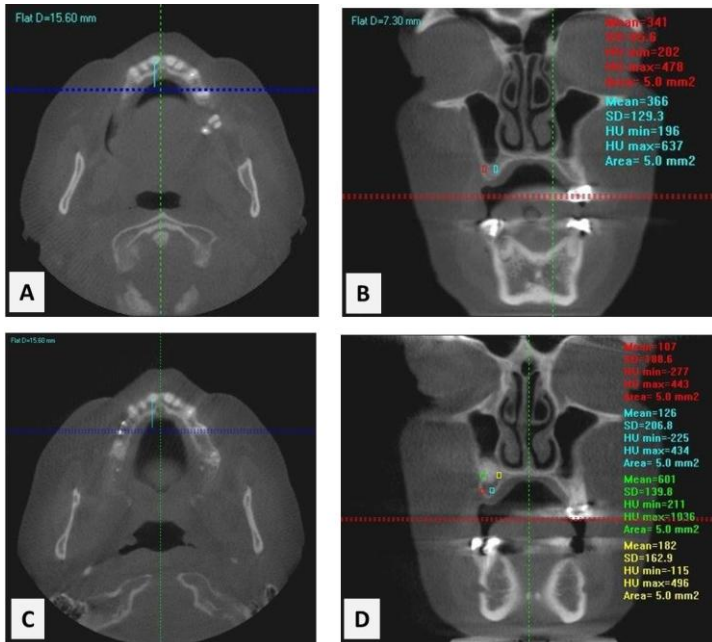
CBCT images of *sinus lift* site measurements in horizontal and coronal incisions before and after *sinus lift* surgery
